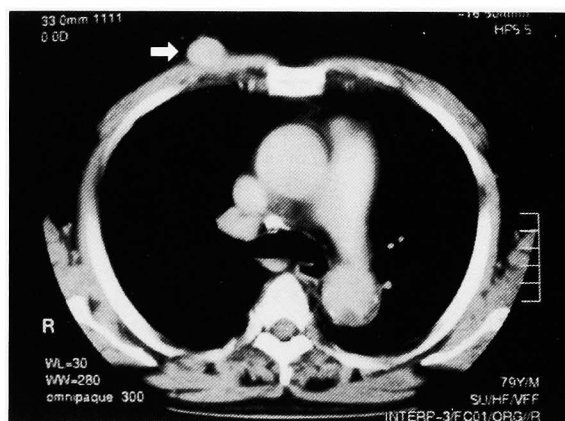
Chest CT revealed a heterogenous solitary mass (arrow) in subcutaneous tissue on right chest wall.
